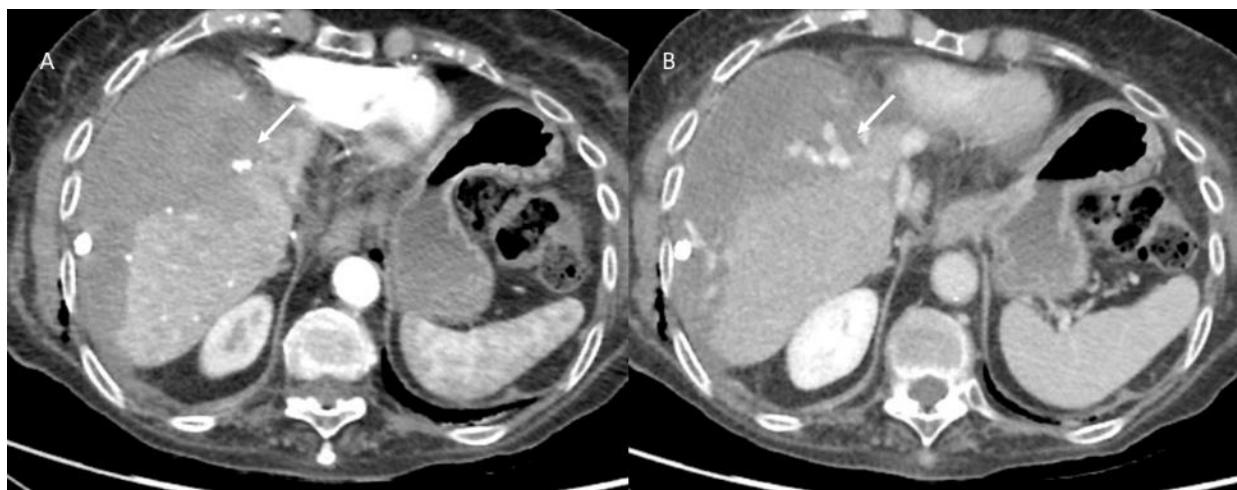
Active bleeding. During arterial CT assessment (A) and portal evaluation (B), arrow shows active overflow of contrast material.
